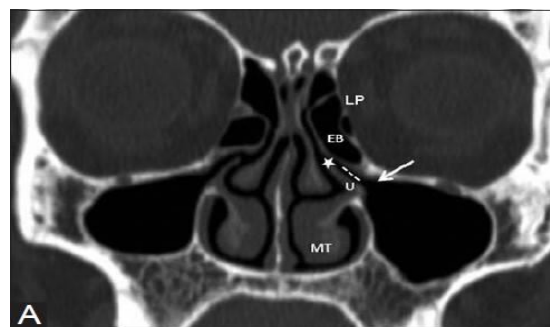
Coronal CT slice at the level of osteomeatal complex showed bulla ethmoidalis (arrow)
